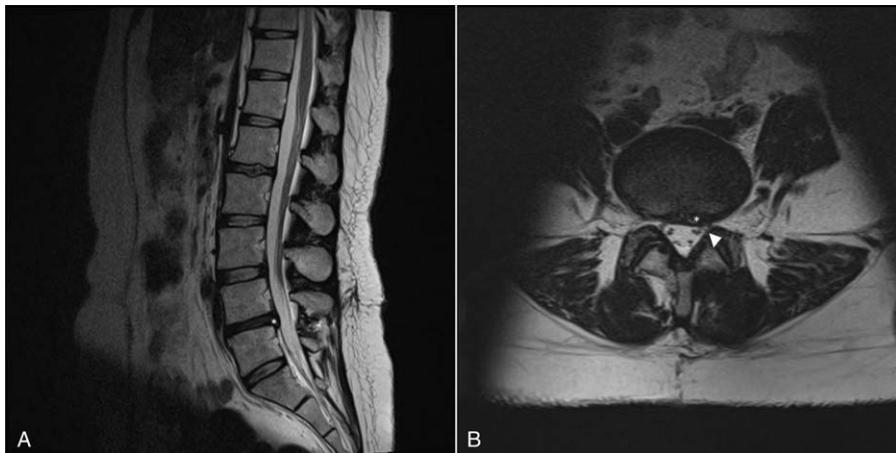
Follow-up MRI at 2 years postsurgery. (A) Sagittal and (B) axial T2-weighted images demonstrated resolution of the herniated disc (asterisk) and no nerve root compression (arrowhead). MRI indicates magnetic resonance imaging.
